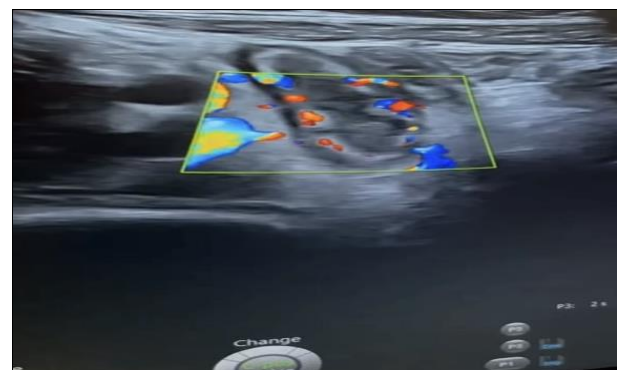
16-year-old boy's sonography revealed a dilated appendix with an edematous wall and signs of inflammation in the appendix, along with acute discomfort and tenderness in the area.
